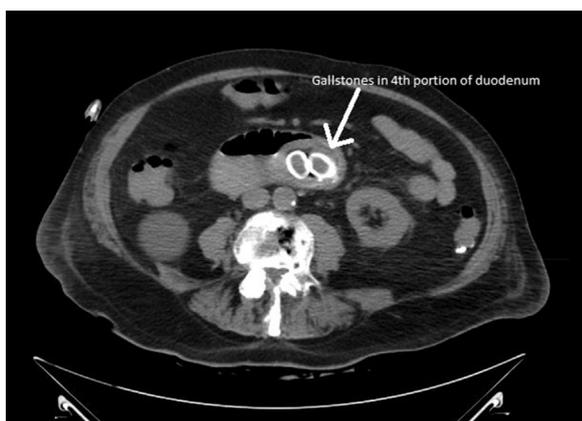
Repeat CT demonstrating migration of gallstone to fourth portion of duodenum.
